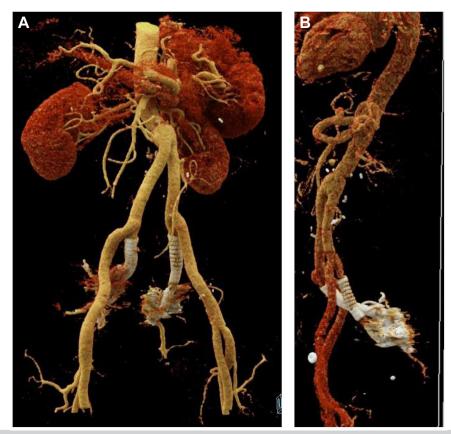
Three-dimensional reconstruction of computed tomography angiogram of the patient's aortoiliac system postoperatively from the anterior (A) and lateral (B) views.
